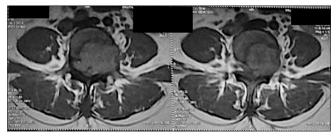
Preoperative axial magnetic resonance imaging (T1-weighted) of L4 pathological fracture with soft tissue showing encroachment of lesion into spinal canal
